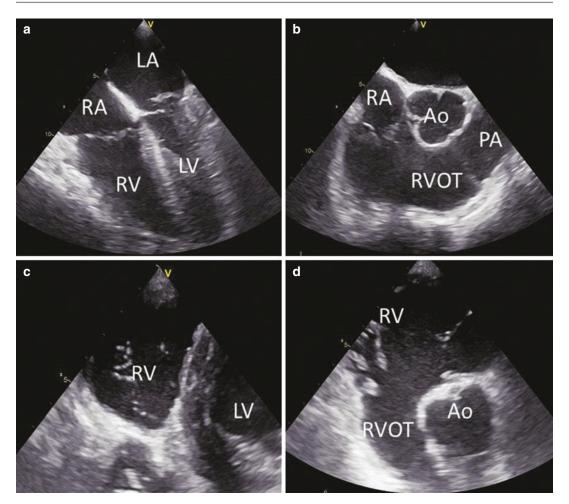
Transesophageal echocardiographic assessment of the right ventricle. The mid-esophageal 4 chamber view at 0° (panel a), the right ventricular inflow-outflow view (at 30–60°, panel b) and the transgastric short- (panel c) and long-axis (panel d) views should be acquired when
